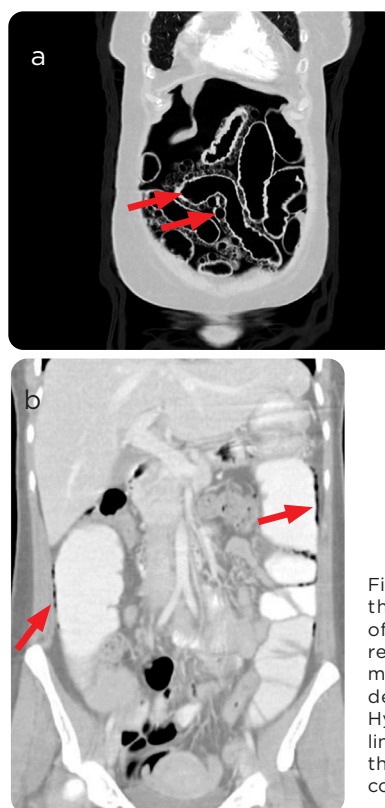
a) Abdominal CT scan that allows a clear definition of the cystic images and their relationship with the intestinal mucosa (arrows), as well as moderate pneumoperitoneum. b) Hypodense muscular images of linear configuration in the wall of the ascending and descending colon (arrows).
